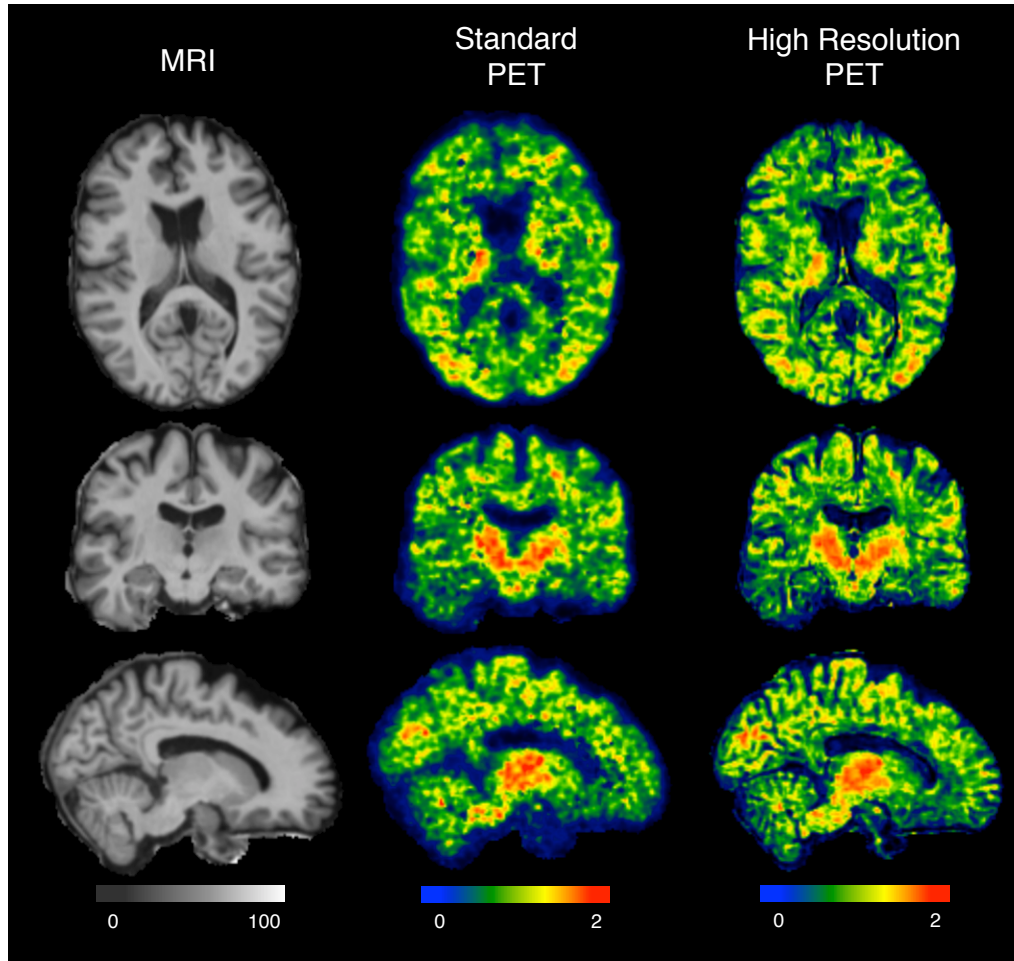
$[^{11}\text{C}]\text{PIB}$ PET axial, coronal and sagittal views from a representative control. Left column MRI images; central column Standard PET; right column High Resolution PET. Color codes for PET images represent DVR units dimensionless
